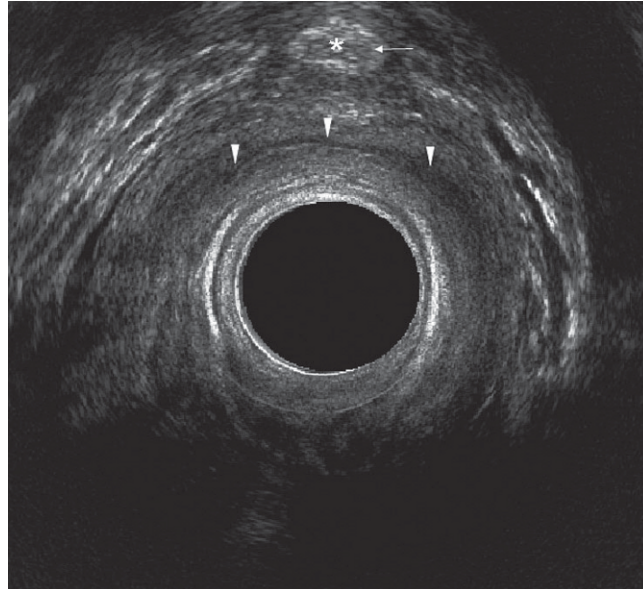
3D ultrasonography with electronic rotating transrectal transducer. Scan above the plane of the sphincter at the level of the hiatus of the levator ani muscle. Axial view of the vagina (*arrowheads*) and the urethra (*U*) with detailed visualization of the submucosa (*arrow*)
